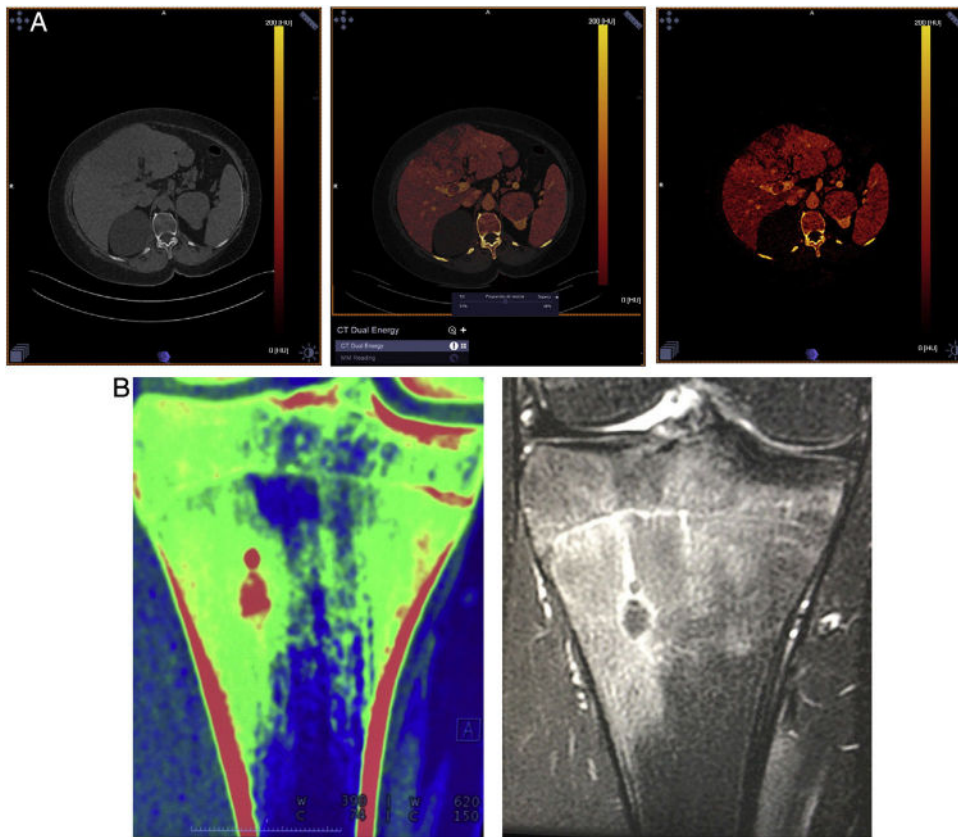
A) Single post-contrast acquisition. Axial plane image of the upper abdomen. Left-hand image, virtual non-contrast (VNC). Central image with iodine map merged with the anatomical image at 50%. Right-hand image, iodine map. B) 19-year-old male diagnosed with osteoid osteoma in the proximal tibial metaphysis. Dual-energy CT, coronal plane and “bone oedema” map image showing bone oedema adjacent to the nidus in green (red). MRI with coronal T2-weighted sequence, with fat saturation showing the extent of bone oedema similar to the CT study.
